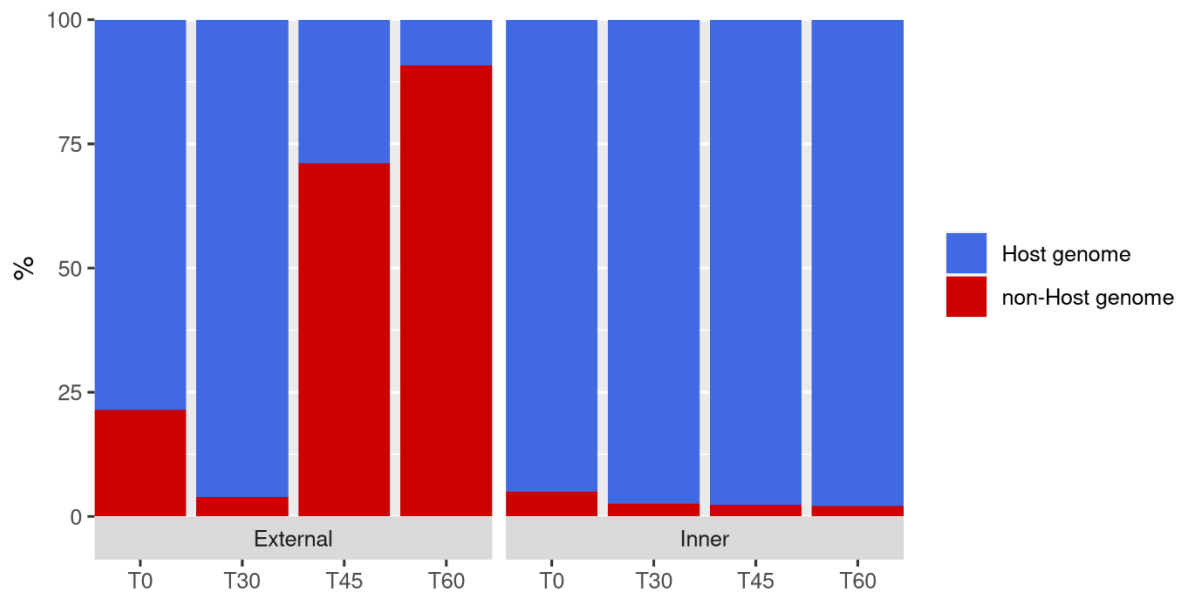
Graphical representation of the composition of the host vs non host genome on external and internal samples of Angus loins (CT).
